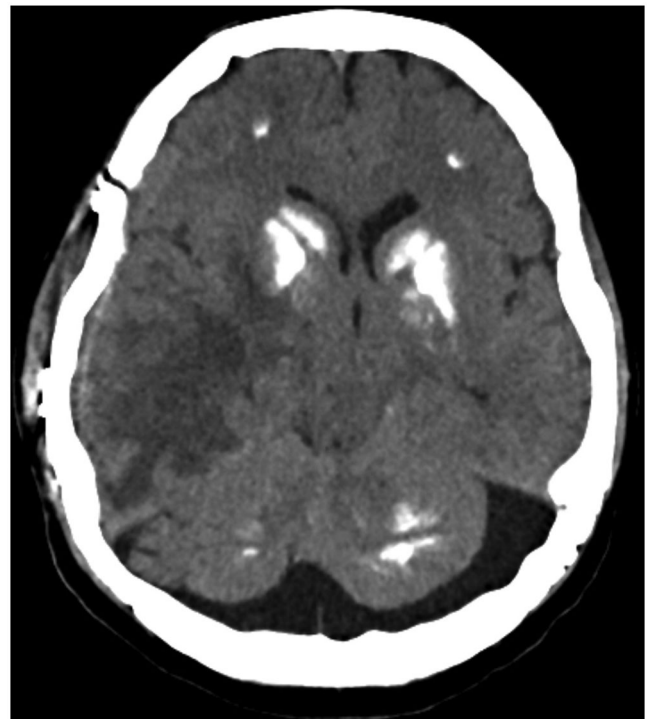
Axial non-enhanced computed tomography shows calcification in bilateral basal ganglia, subcortical area and cerebellar dentate nuclei consistent with Fahr's disease.
